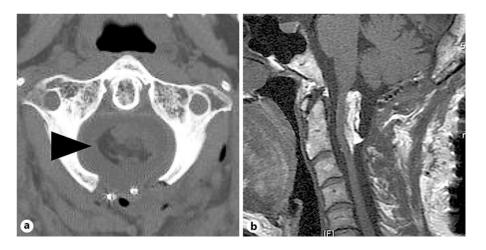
a An axial image of a computed tomography scan at the C1 level shows decreased volume of the mass (black arrowhead) and laminectomy performed. b Sagittal T1-weighted magnetic resonance imaging shows partial removal of the lipoma.
